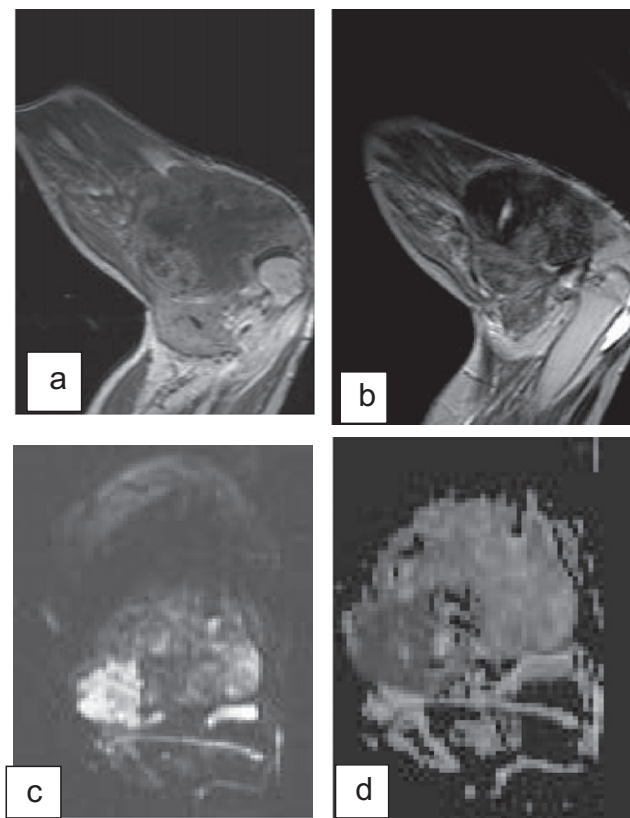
Osteosarcoma of the forearm appears of low signal in sagittal T1WIs (a), heterogeneous high signal in sagittal T2WIs (b). Area of restriction in DWI (c, d) and ADC. ADC Value 0.9 ± 0.6 .
